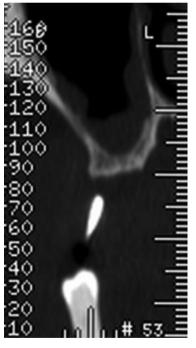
Pre-op CT scan, control side.
